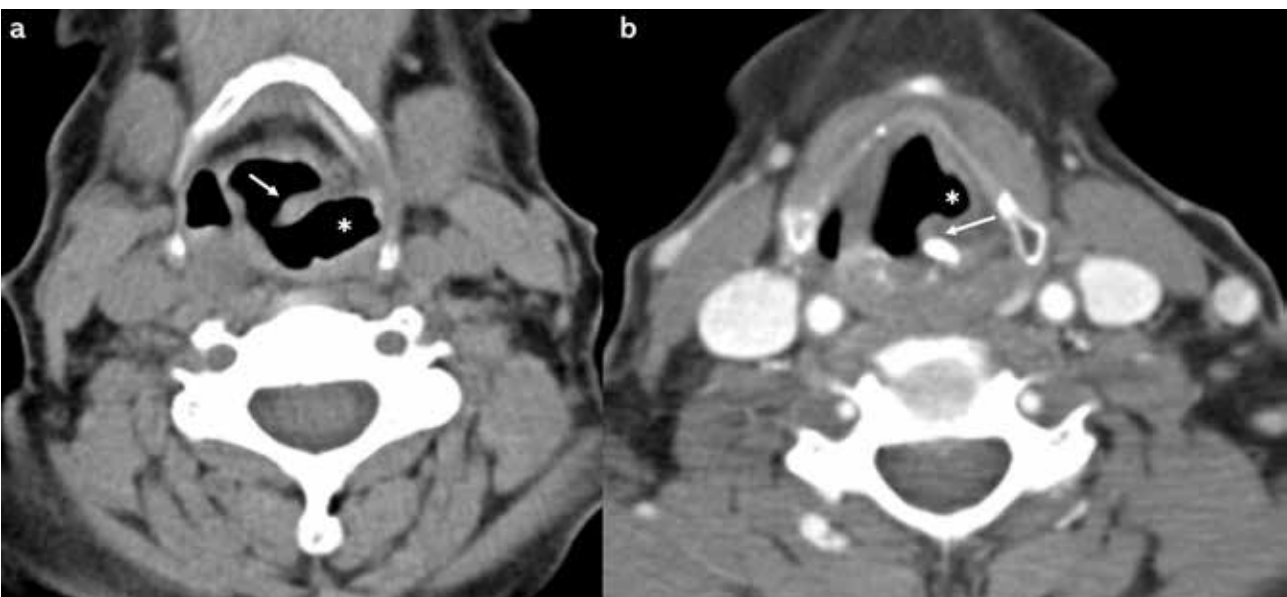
Contrast-enhanced neck CT (quiet respiration) – a) At the level of the hypopharynx, there is distention of the left piriform sinus with air (*) and medial rotation of the ipsilateral aryepiglottic fold (arrow) b) Inferiorly, at the level of the vocal cords, the left aryepiglottic cartilage is anteromedially rotated (arrow) and the ipsilateral laryngeal ventricle is enlarged - sail sign (*). These are consistent with left vocal cord paralysis.*
